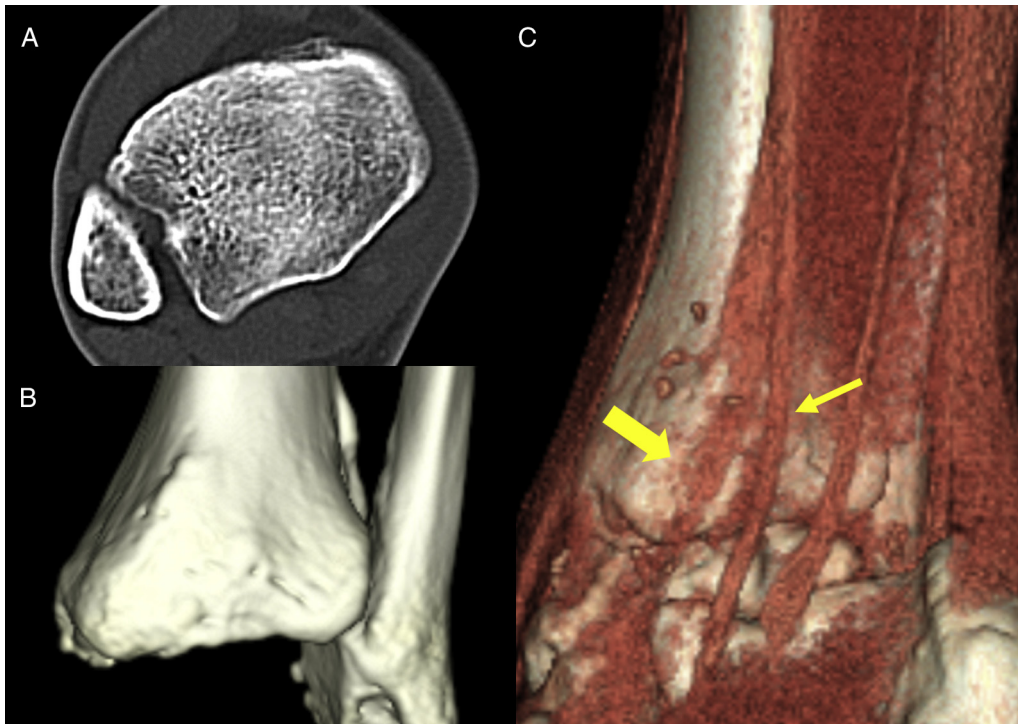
Preoperative plain and 3-dimensional computed tomography scan showing a flat retromalleolar groove. (A and B) The posterior tibial tendon (*thick arrow*) lies on the flattened groove in a volume-rendered image. (C) View of a flexor digitorum longus tendon (*thin arrow*).
